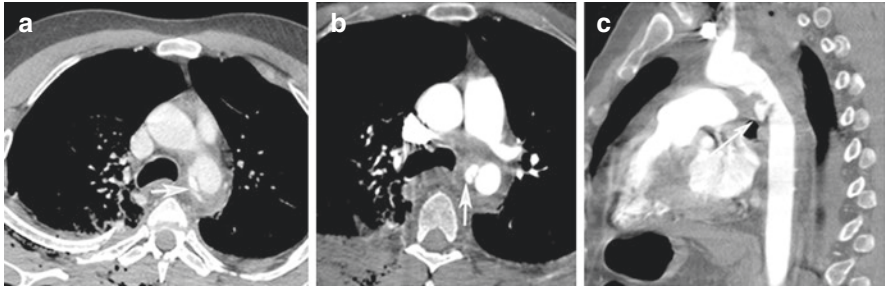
Postcontrast computed tomography (CT) of aortic traumatic injury. (a) Axial postcontrast CT image showing a posttraumatic aortic dissection at the level of the aortic isthmus. An intimal flap is present with aortic contour irregularity and extravasation of contrast medium (white arrow) associated with a mediastinal hematoma. (b) Axial postcontrast CT image showing a posttraumatic aortic pseudoaneurysm at the level of the aortic isthmus (white arrow) associated with a mediastinal hematoma. (c) Oblique sagittal postcontrast CT reconstruction showing a posttraumatic aortic pseudoaneurysm at the level of the aortic isthmus with contrast agent outpouching extending beyond the aortic wall (white arrow). (Courtesy of the Department of General and Emergency Radiology, A. Cardarelli Hospital, Naples, Italy). Reprinted, with permission, from Bossone E, et al. Acute Aortic Syndromes: Diagnostic and Therapeutic Pathways. Heart Fail Clin. 2020;16(3):305–315 [9]
